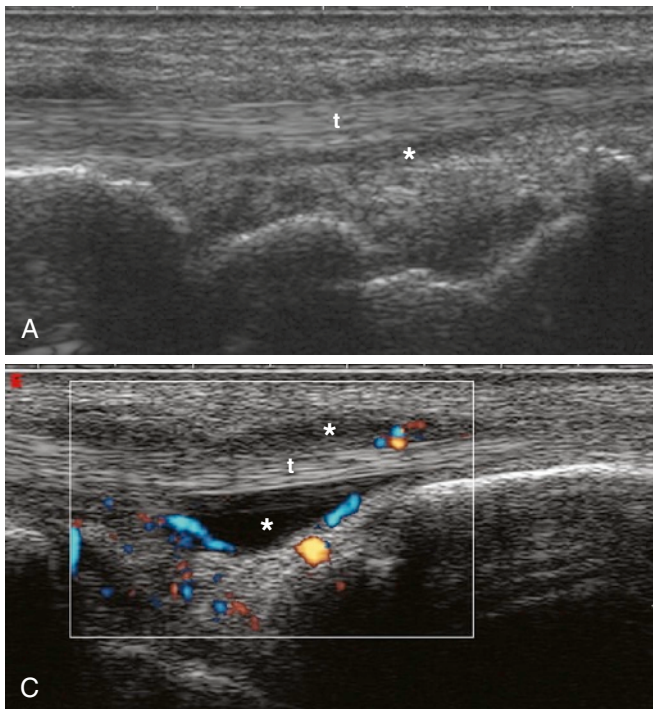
Scans reveal tenosynovitis (*stars*) of the extensor digitorum tendons (t). A, Longitudinal scan. B, Transverse scan. C, Tenosynovitis (*star*) of the extensor digitorum tendon (t) is identified with power Doppler activity.
